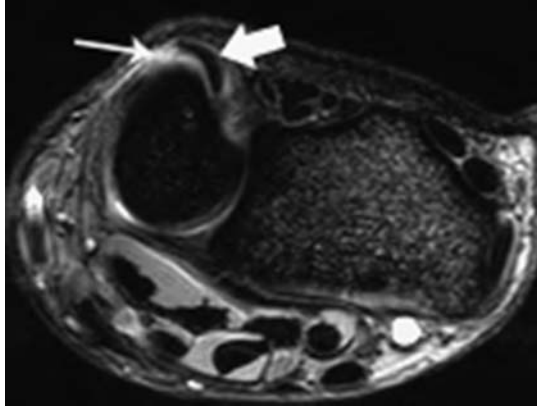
Axial T2 fat-saturated MRI of the wrist performed in slight supination shows subluxation of the ECU tendon (thick arrow). The fibro-osseous sheath is stripped medially (thin arrow).
